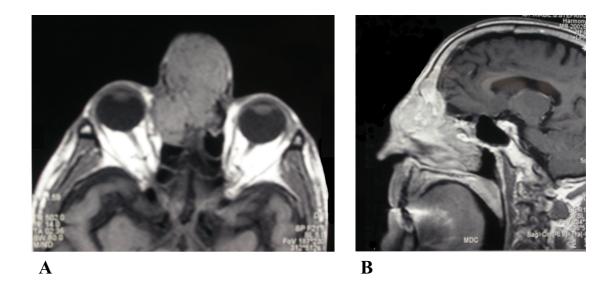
MRI in the axial (A) and sagital (B) planes showing a soft tissue ethmoid mass extending to the right and left choanal region, the right orbit, the right frontal sinus and an initial intracranial extension with partial erosion of the crista galli.
